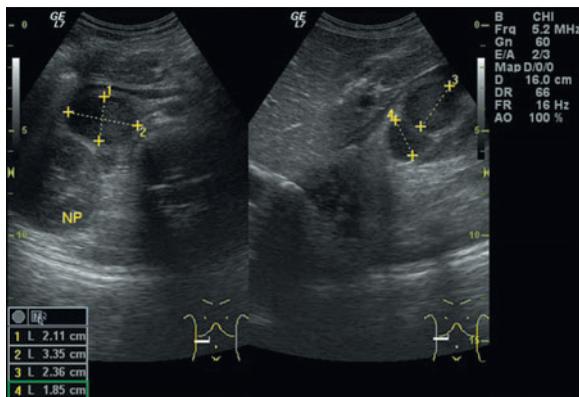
Girl WE. Transabdominal sonography – numerous, hypoechoic tumors situated in the paravertebral region.
